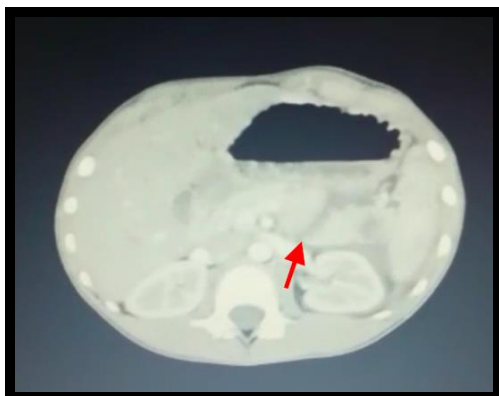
Contrast of Abdomen CT Scan; laceration with hematoma in the tail region of the pancreas, with free fluid in peripancreatic, perisplenica, left side abdomen and perivesika.
